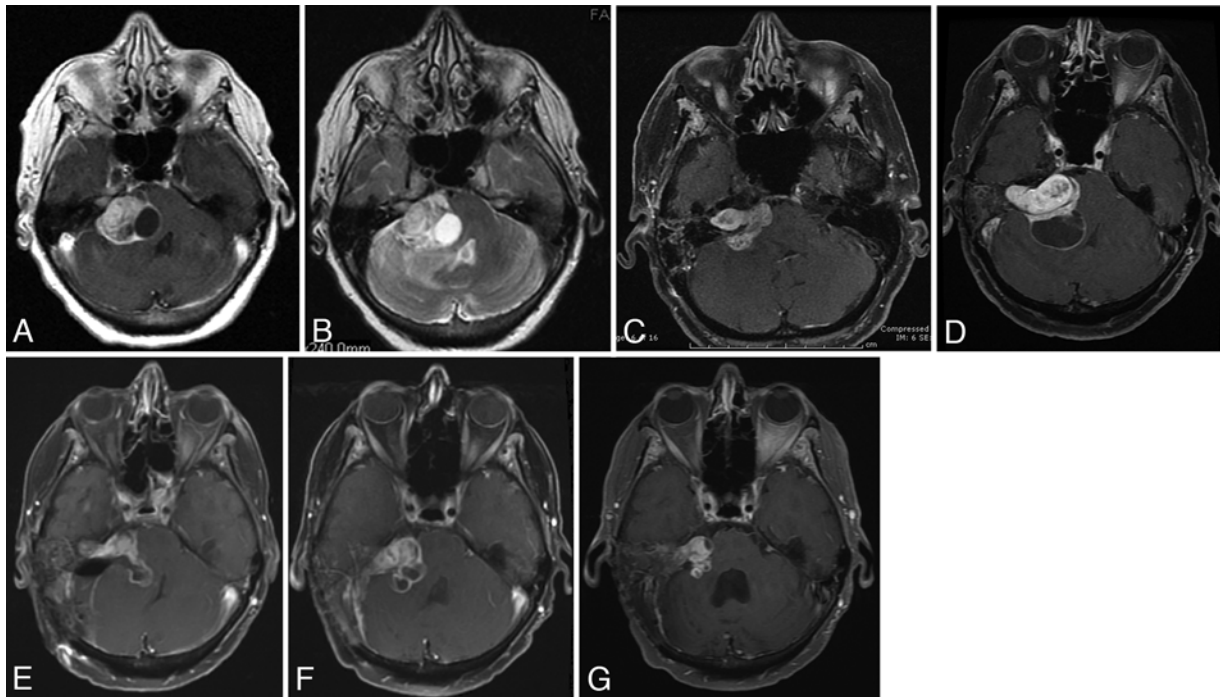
Images obtained in a 66-year-old woman presenting with hearing loss, right facial sensory disturbance, and vertigo. Preoperative T1-weighted contrast-enhanced MR image (A) demonstrating a right VS with multiple small cysts and a single large medial cyst adjacent to the brainstem. Axial T2-weighted MR image (B) revealing the classic appearance of CVS with hyperintense signal within the cyst. Postoperative MR image (C) obtained after a translabyrinthine approach, showing residual tumor after STR. Axial MR image (D) obtained 1 year after the image featured in panel B, demonstrating interval development of a large medial cyst with significant compression of the pons and cerebellum. Postoperative axial MR image (E) obtained immediately after a second craniotomy (retrosigmoid approach), demonstrating significant debulking of the tumor, brainstem decompression, and cyst resection. Follow-up MR image (F) obtained 8 months later, showing tumor recurrence along with 2 small medial cysts, which prompted adjuvant external radiation treatment with 5040 cGy. Axial MR image (G) obtained 2 years after the completion of radiation, showing a mild decrease in the size of the 2 small cysts and the residual tumor.
